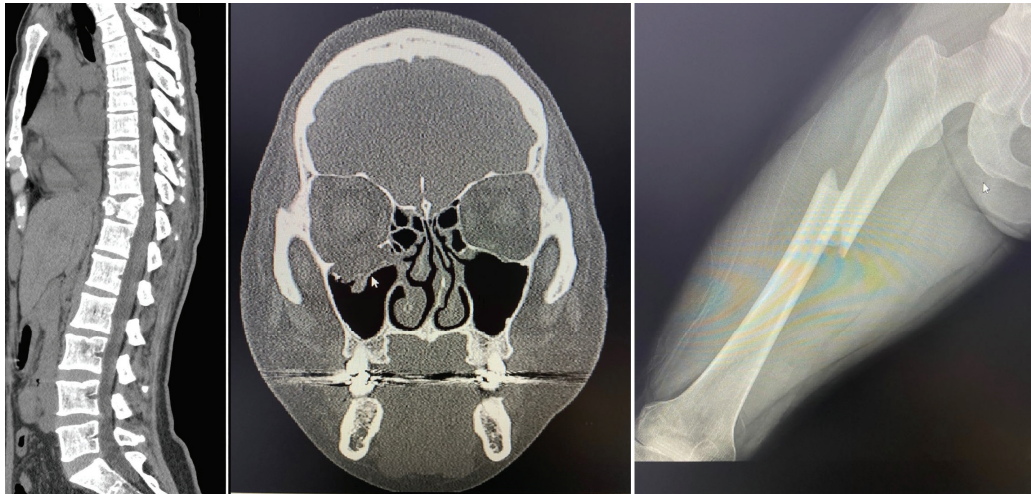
Preoperative radiographs of the patient. T11 Spine body fracture, blow-out fracture of the right maxilla, and right femur shaft fracture.
